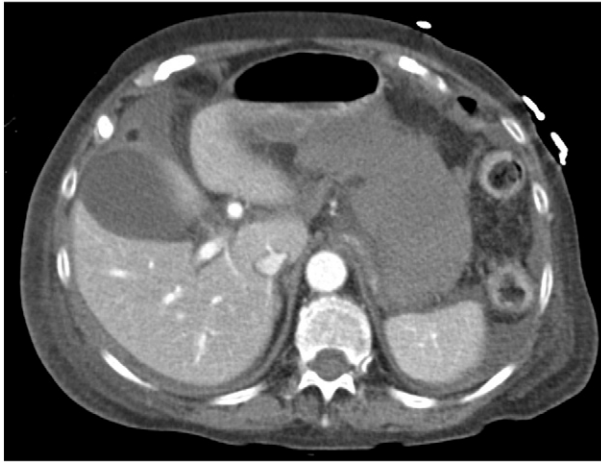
CT-Scan 04/15/2014. Free abdominal fluid surrounding liver and spleen.
